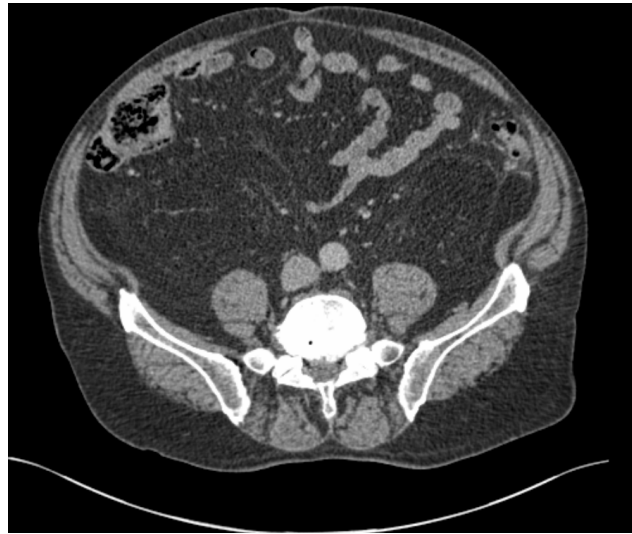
An example CT scan of the pelvis and spine. This image from the Addenbrooke's Hospital CT Data Collection.
